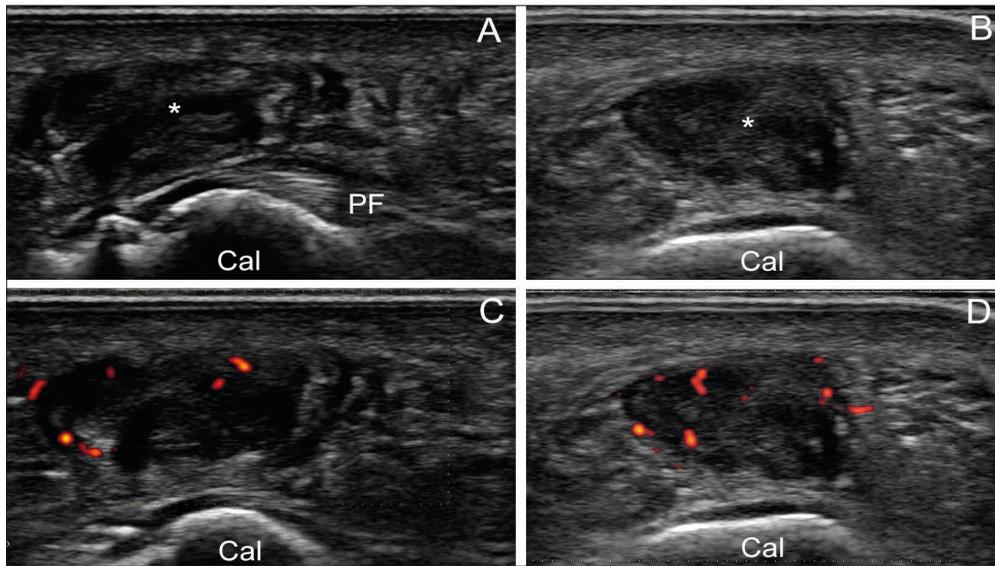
Sonogram of subcalcaneal bursitis in the left plantar heel (Case 1). The long axis (A) and short axis (B) gray-scale sonograms show a well-demarcated predominantly hypoechoic and partially anechoic mass within the plantar fat pad. The long axis (C) and short axis (D) power Doppler sonograms show mild hyperemia at the margin and inside of the lesion. Cal, calcaneus; PF, plantar fascia.
